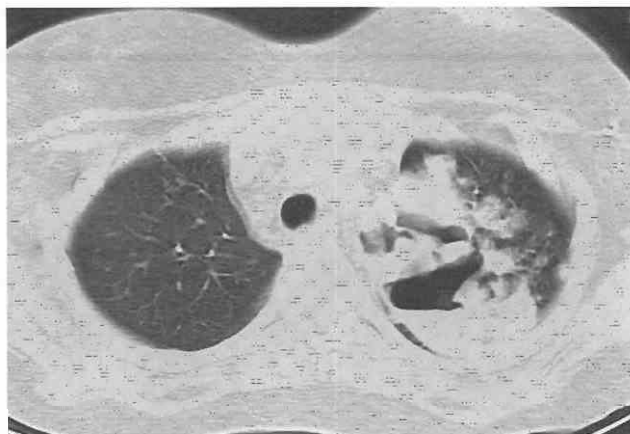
Fungal pneumonia in a 17-year-old liver and kidney transplant recipient. CT scan shows large cavitary process containing an air-fluid level in the left upper lobe. Multiple clustered nodules are adjacent to the cavity.
